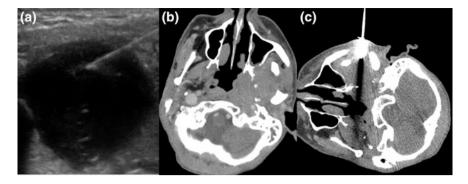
Image-guided biopsies. a US-guided fine needle aspiration of a metastatic squamous cell carcinoma lymph node. b Pre-procedure contrast CT and c CT-guided trans-zygomatic biopsy of the infratemporal fossa in a patient with recurrent squamous cell cancer of the tonsils (*asterisk*)
